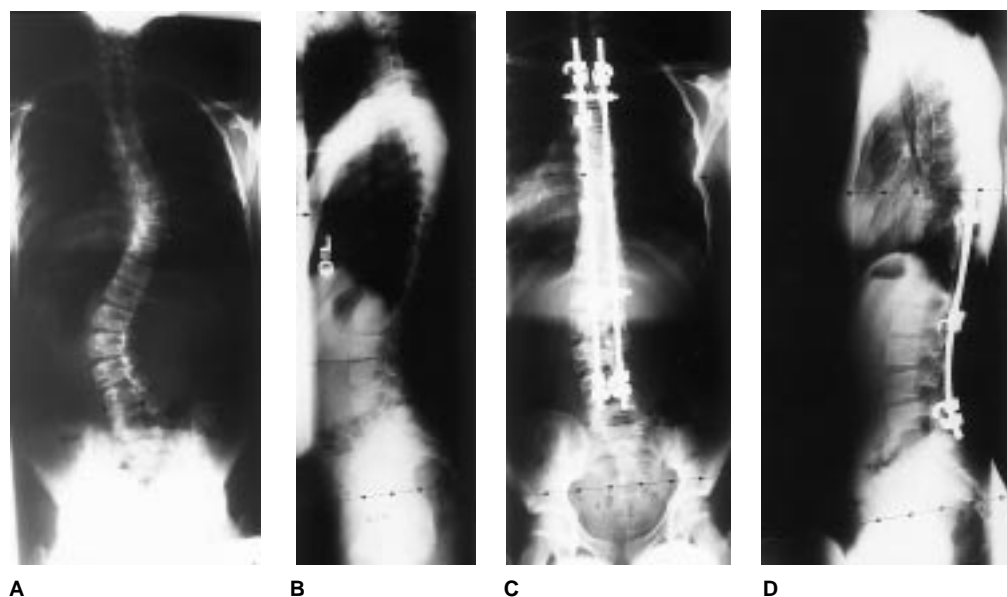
A and B, Preoperative radiographs of a girl aged 11 years 1 month with a 47-degree right thoracic curve and a 47-degree left lumbar curve. C and D, Postoperative radiographs of same patient at age 11 years 6 months, after posterior spinal fusion performed with Isola instrumentation, show a 10-degree right thoracic curve and a 17-degree left lumbar curve.
